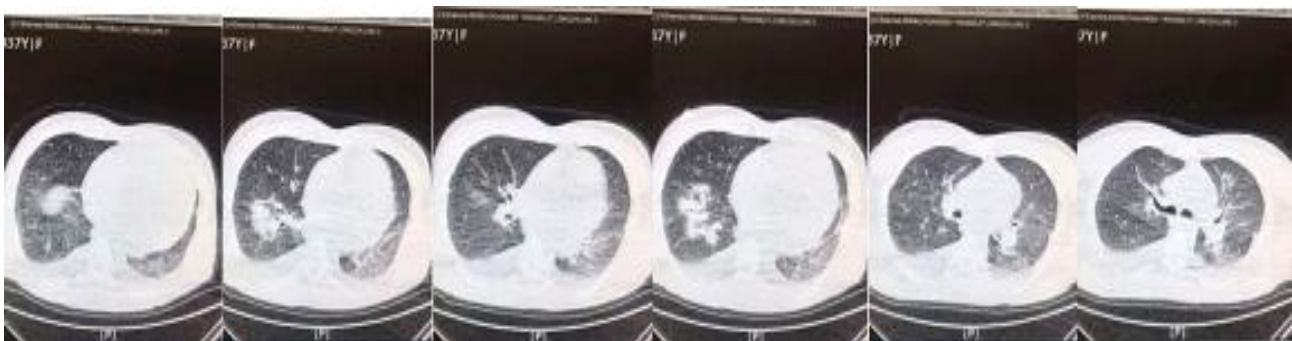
CT scan mild diffused ground glass opacities more prominently in RLL. Patchy air space and ground glass opacities both lung fields.
